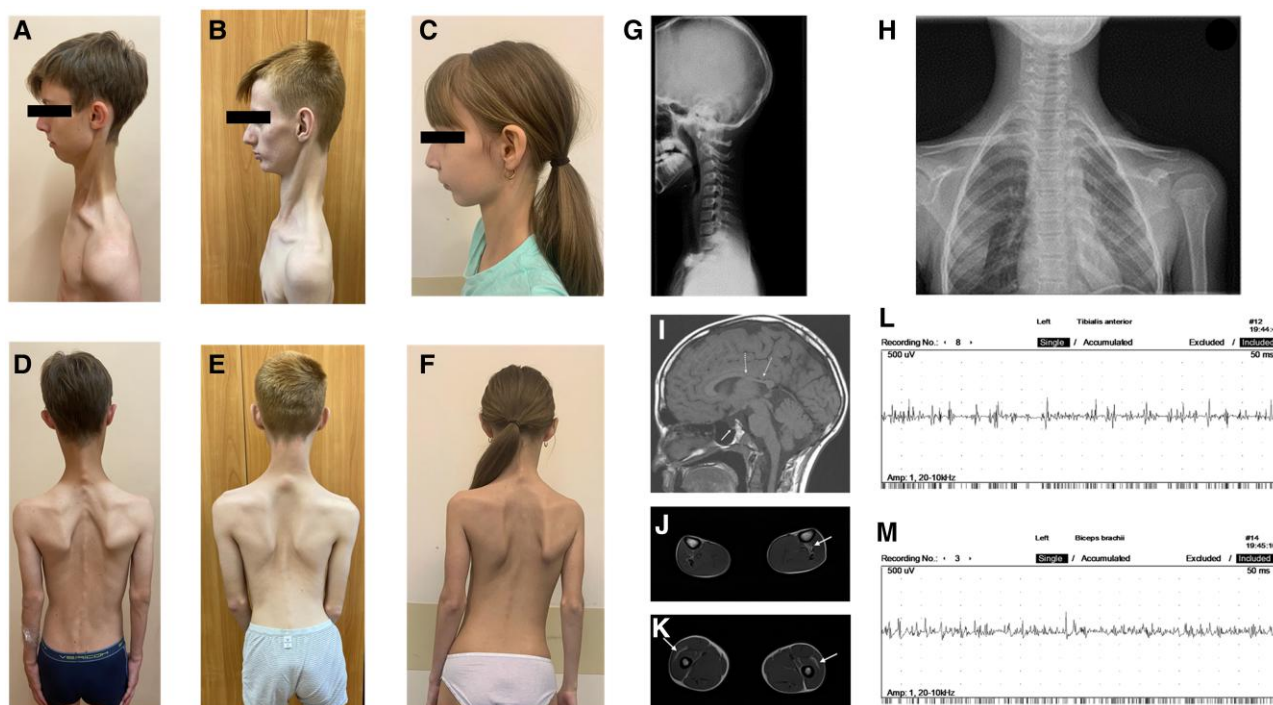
Clinical features of patients with amyotrophy, testicular failure, and mild intellectual disability with or without short stature. (A-F) Phenotype of patient 3 (A, D), patient 1 (B, E), and patient 5 (C, F) showing extremely reduced body weight, atrophy of the paravertebral muscles, long neck, scoliosis, and mild facial dysmorphic features. (G, H) X-ray of patient 3 with cervicalization of thoracic vertebrae and thoracic scoliosis. (I) Sagittal MRI of patient 3 in T1-weighted image. White arrows indicate hypoplasia of the corpus callosum and partial empty sella syndrome. (J, K) Lower limb muscle MRI in T1-weighted image of patient 1 with involvement of m. vastus intermedius and m. tibialis posterior indicated with white arrows. (L, M) Electromyography of n. tibialis anterior and n. biceps brachii of patient 1 displaying signs of myopathic changes.
